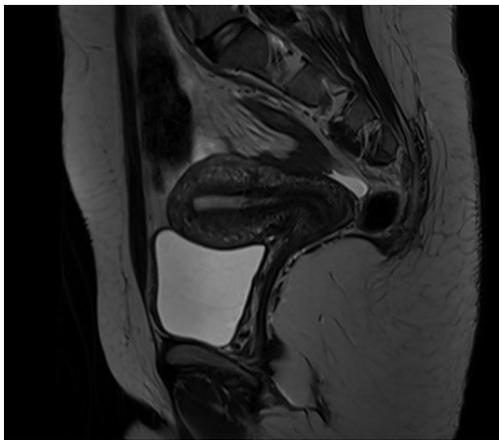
Pretreatment pelvic MRI showing thickened endometrium.
